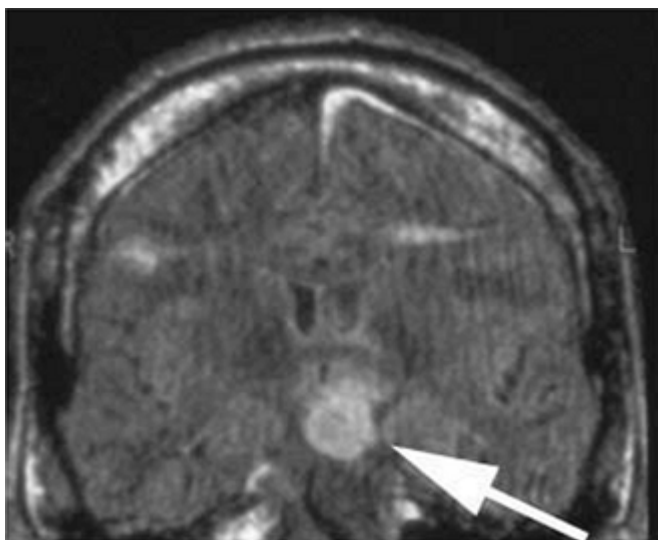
Coronal magnetic resonance imaging scan of a patient with a hypothalamic hamartoma. The hamartoma had been treated with stereotactically guided radiofrequency ablation a few days before.
